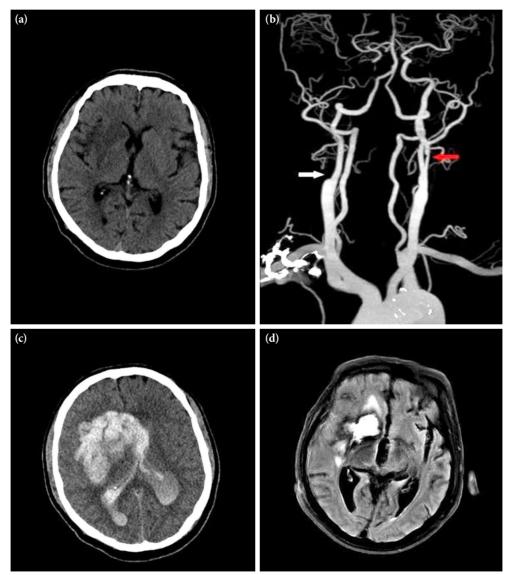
CT and MRI, angiography of the brain. (a) Cranial CT showing low density signals in the right basal ganglia and frontal lobe. (b) CT angiography revealed occlusion of the right ICA (white arrow) and stenosis of left proximal ICA (red arrow) (c) Cranial CT demonstrated a large right basal ganglia hematoma with intraventricular extension and midline shifting. (d) T2 FLAIR MRI of the brain three months after the stroke.
